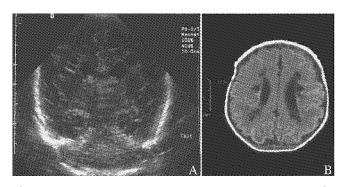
Periventricular leucomalacia following maternal MDMA abuse. A: echoencephalography; B: magnetic resonance imaging.
